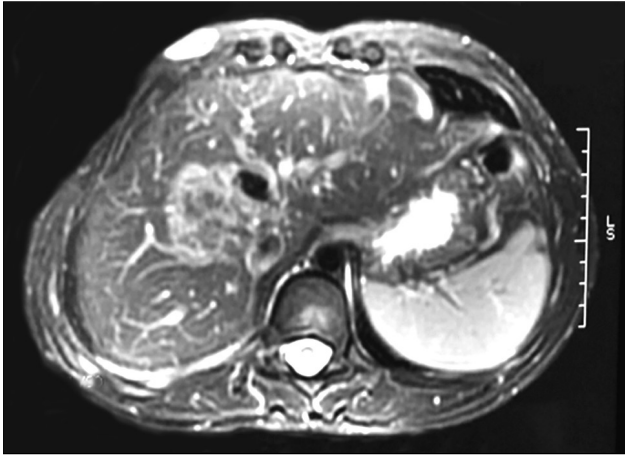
MRI that shows the relation of the tumor with the inferior vena Cava and the suprahepatic veins
